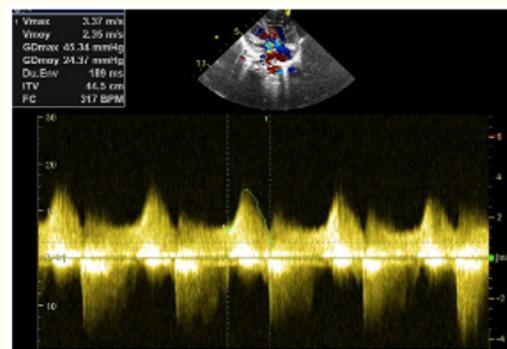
Continuous doppler quantifying the peak and mean trans atrioventricular valve gradients.
